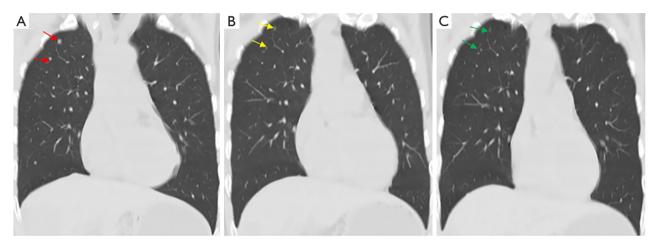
CT scan revealed the pulmonary metastases before treatment (A), the change of tumor after third treatment cycle (B), and after ninth treatment cycle (C).
